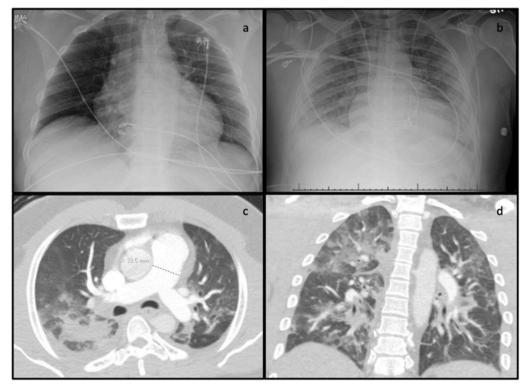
Select chest imaging in FES. CXR on day of admission (a) and hospital day three (b) showing interval development of diffuse bilateral hazy opacities. CT Angiography of lungs at three days after initial injury in axial (c) and coronal (d) sections. Note dilated pulmonary trunk in (c) and presence of diffuse infiltrates and ground glass opacities, consistent with RV strain in the setting of hypoxic respiratory failure. CT = computer tomography; CXR = chest X-ray; FES = fat embolism syndrome; RV = right ventricle.
